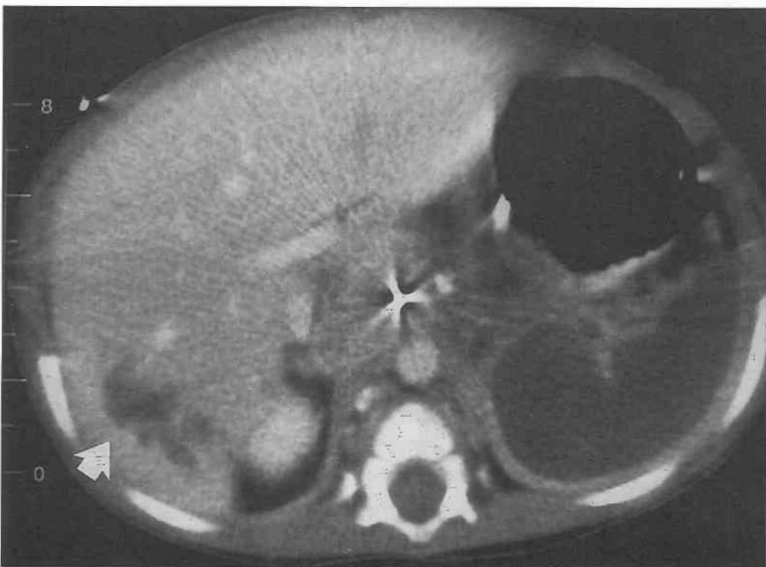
Iatrogenic injury resulting in complete splenic infarction. This CT image is from an 8-month-old boy who underwent surgical resection of a large neuroblastoma in the left upper quadrant. Helical CT image reveals no contrast enhancement of the spleen except for its rim, because of capsular artery supply. A liver hematoma can be visualized in the posterior right lobe (arrow).
